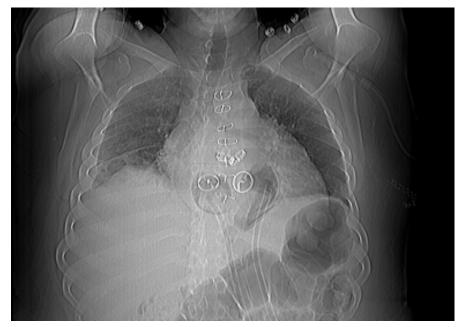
Postoperative CT showing the pneumatics pumps, mechanical valves and drivelines.
